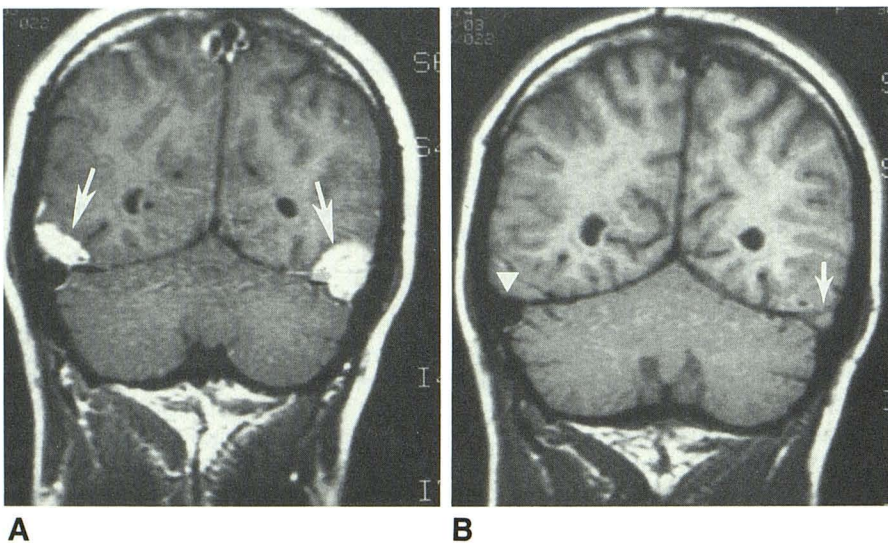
A, Coronal Gd-DTPA-enhanced MR image (spin echo, 500/20) shows high-signal lesions inferior to occipital lobes bilaterally (arrows). These correspond with CT scans (see Fig. 1).
